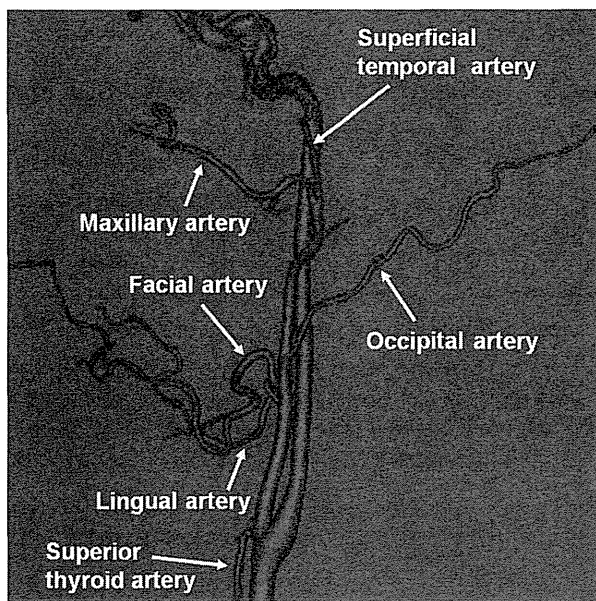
Three-dimensional computed tomography angiography of the external carotid artery and its branch
